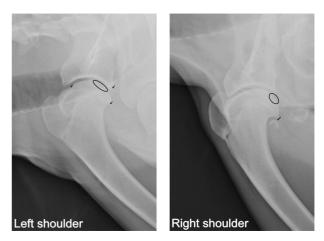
Radiography on both shoulder joints. In left shoulder, a radiolucent line (circle) existed and also some osteophytes (arrows) existed. In right shoulder, subchondral bone defect (circle) was identified and also mineral opacity substance (arrow) was discovered.
